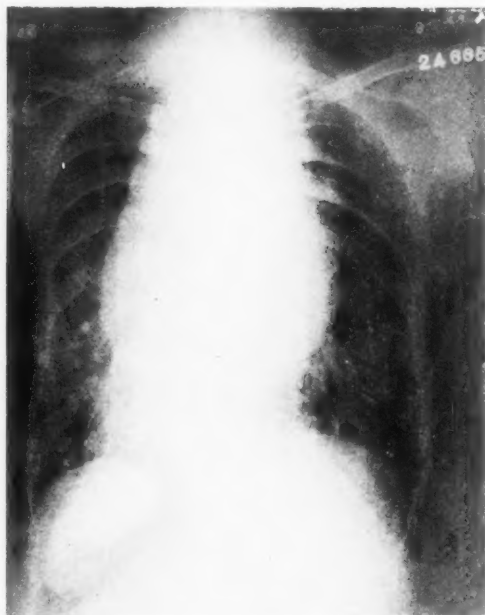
Case 246651. Pott's disease. Clinical findings: Neuralgic pain; rigidity of spine; kyphus; evidence of tuberculosis elsewhere; dactylitis; bronchitis; dullness and absence of systolic sounds in interscapular area. x-Ray shadow: Fusiform, symmetric, superimposed on spine, with accompanying destruction of vertebræ. Narrowed costal angles.
